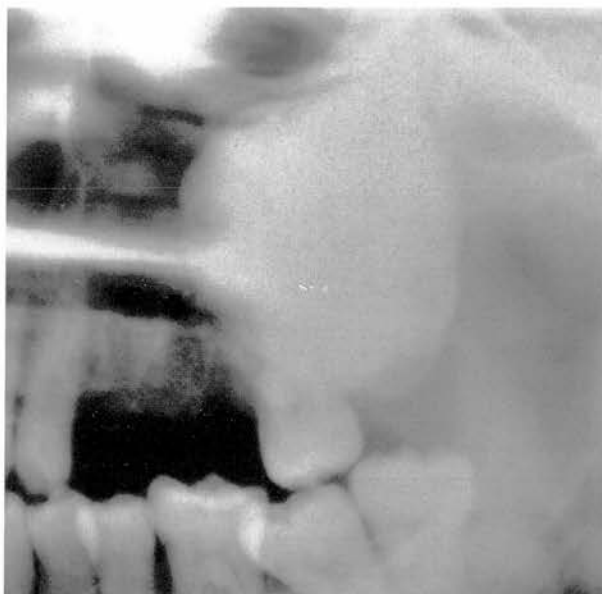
Part of a panoramic radiograph showing a large round complex odontoma occluding the posterior portion of the left maxillary antrum. It has expanded the posterior wall of the maxillary antrum. Figure taken from Ref. 63 with permission.
